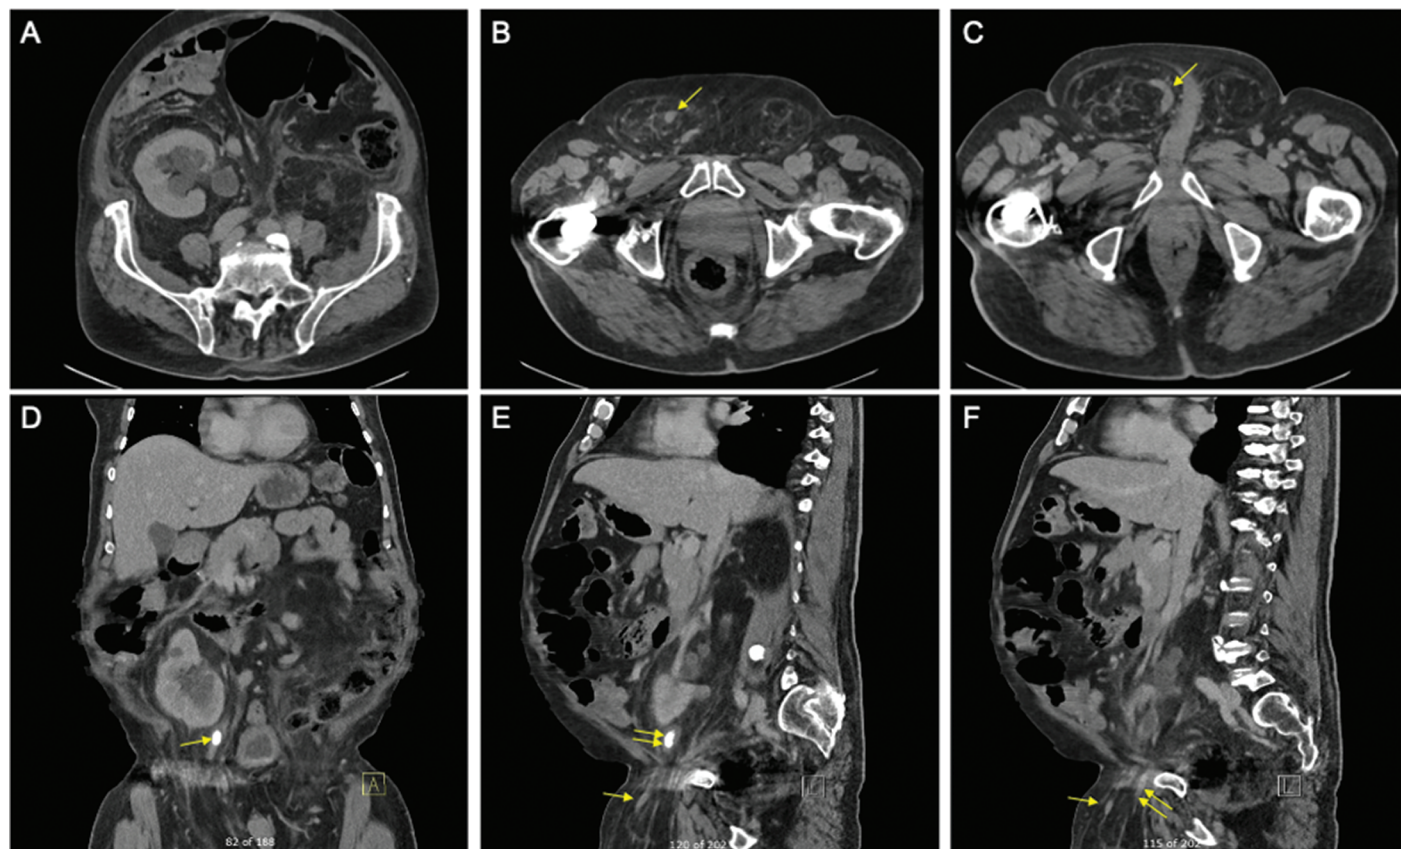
CT scan cross-sectional axial (A-C), coronal (D), and sagittal (E, F) images of kidney, ureters, and bladder: A, Low-lying hydronephrotic kidney with perinephric fat stranding. B, A segment of the ureter (arrow) along the inguinal hernia. C, A loop (arrow) of the herniated ureter. D, The 12-mm ureteric stone (arrow) with upstream hydronephrosis. E, The 12-mm ureteric stone (2 arrows) and the ureter through the inguinal hernia. F, The ureter going in (arrow) and out (2 arrows) the inguinal hernia.
